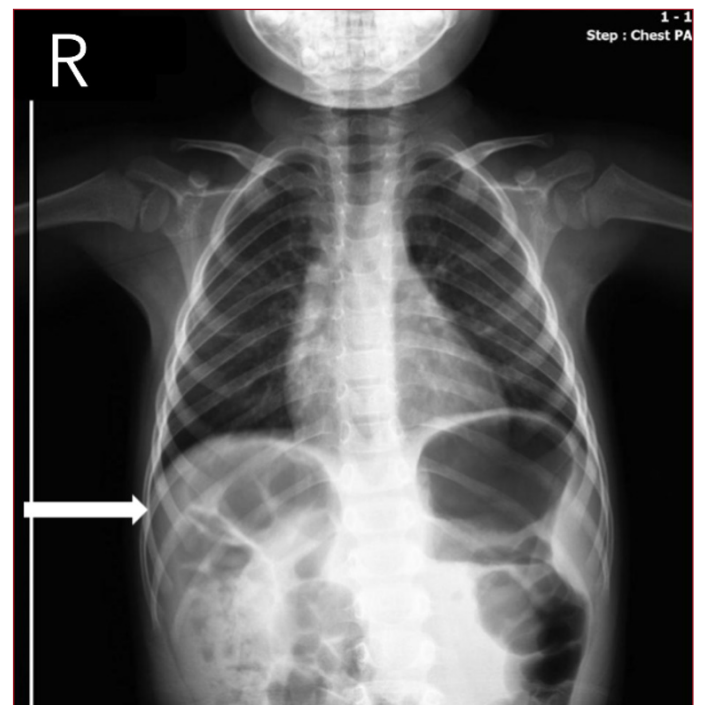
Arrow on X-ray highlights gas between the liver and diaphragm and haustra
